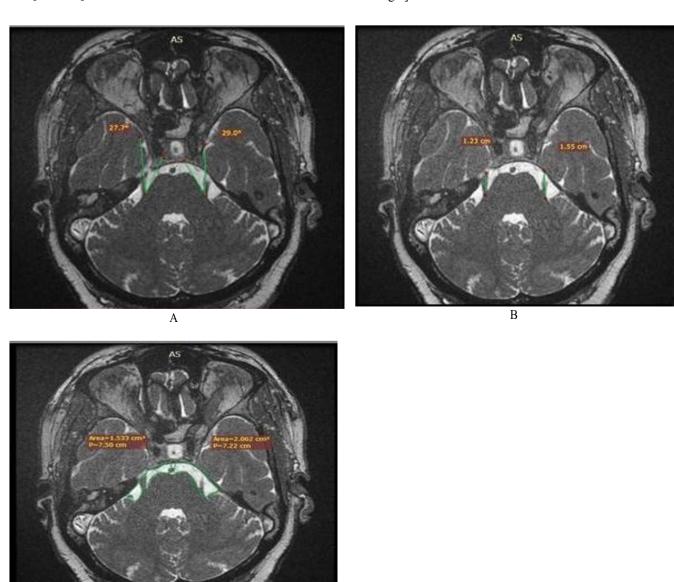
MRI brain of the second case
